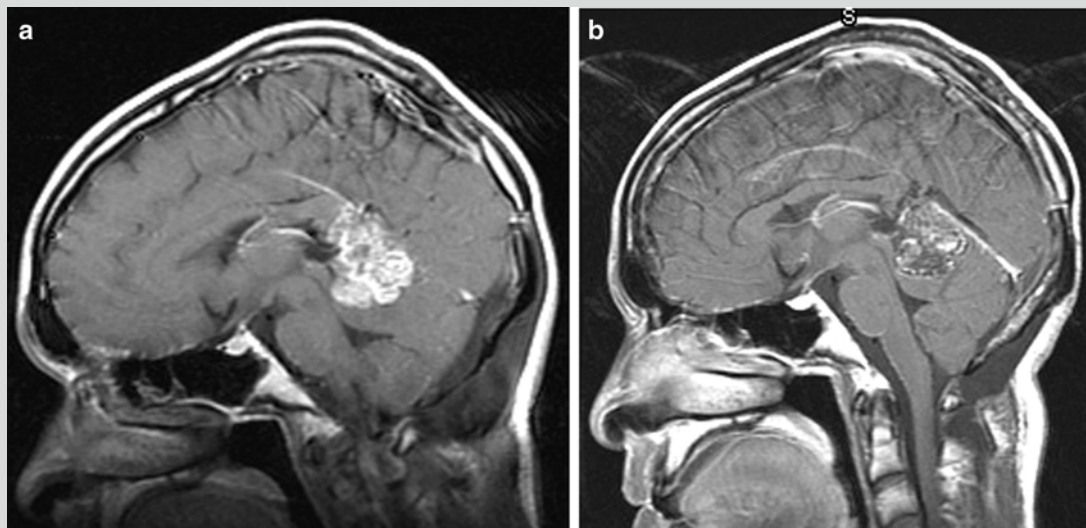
A 20-year-old man presented with pineoblastoma, treated with GKRS boost after craniospinal irradiation. Sagittal gadolinium-enhanced MRI at the time of GKRS (a), compared to that on
